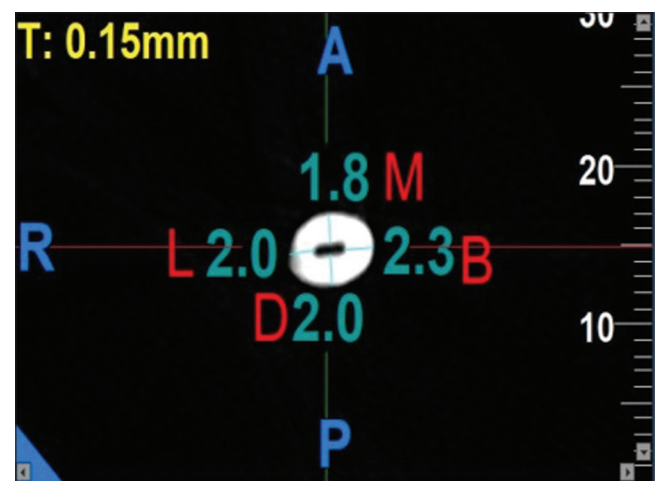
Baseline radicular dentin thickness (4 mm from radiographic apex)
